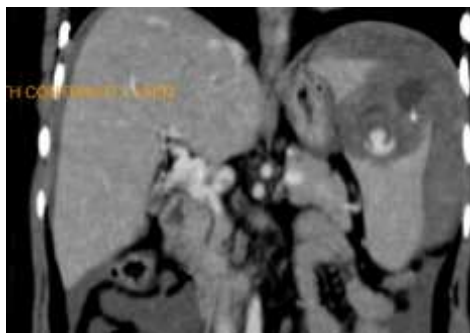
Coronal CT abdomen showing perisplenic hematoma with splenic rupture
